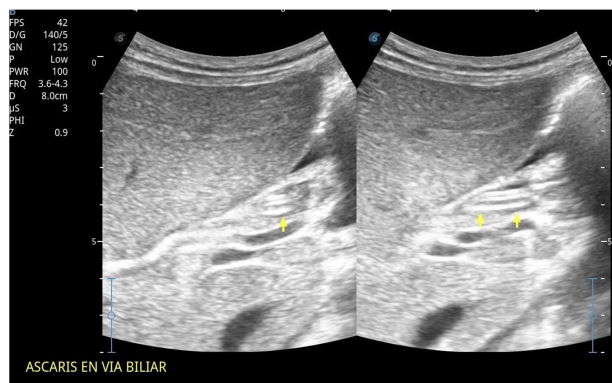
Abdominal ultrasound demonstrating the presence of an *Ascaris lumbricoides* worm within the biliary tract, appearing as a tubular, hyperechoic, consistent with biliary ascariasis.
